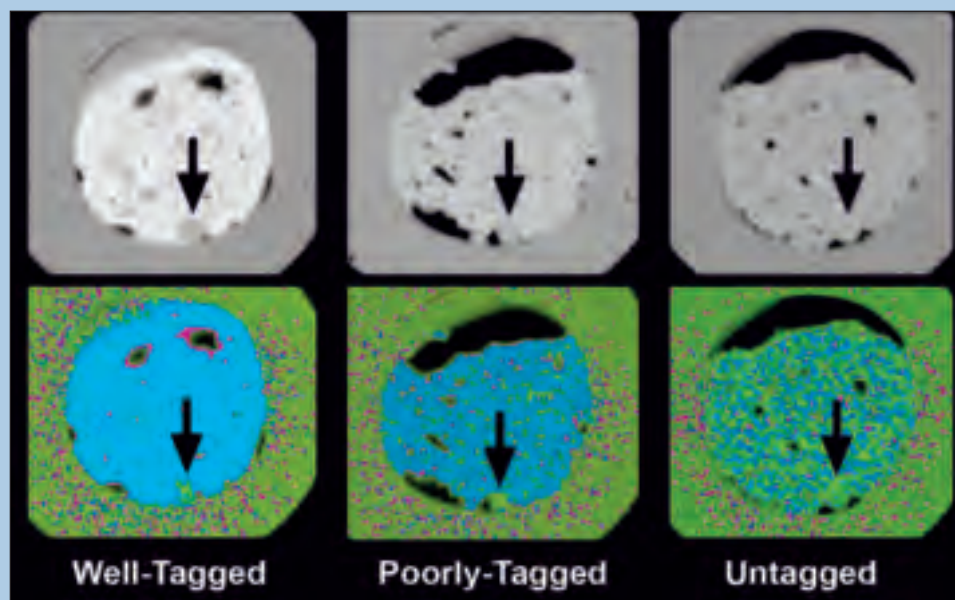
Dual-energy CT electronic stool subtraction. An experimental colon model with an 8 millimeter polyp (arrow) was scanned three times using the dual-energy CT colonography technique and with well-tagged, poorly tagged, or untagged stool (top row). At regular CT colonography, it is difficult to identify the polyp when the stool is poorly or untagged. The bottom row shows dual-energy CT stool maps where soft tissue is color-coded green, and stool is color-coded blue. With the dual-energy CT overlay, the polyp can be more confidently seen with the poorly tagged and untagged scans. Some image noise is present due largely to the use of a low-radiation dose CT imaging technique.
